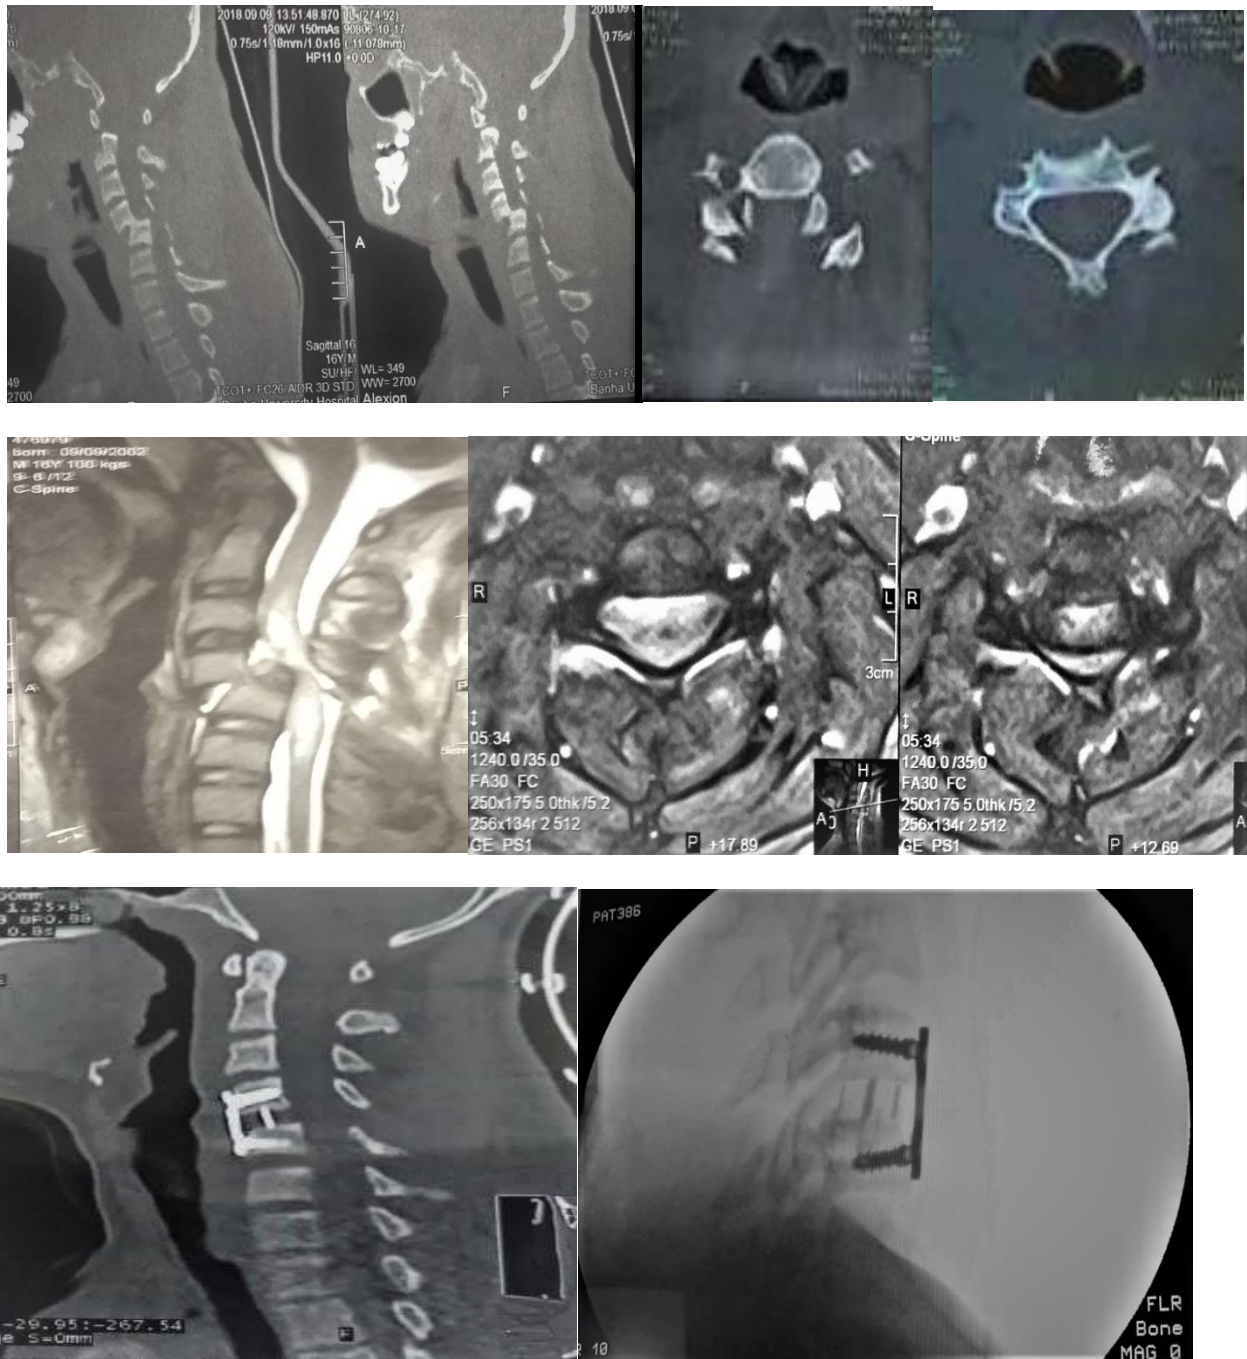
(A): CT cervical spine with C4-5 subluxation in sagittal views and bilateral locked facet in axial views. (B): MRI T2 (sagittal and axial views) cervical spine with C4-5 subluxation, with G2 signal intensity and cord compression. (C): CT cervical spine with C4-5 cage with plate and screws. C arm image intraoperative
